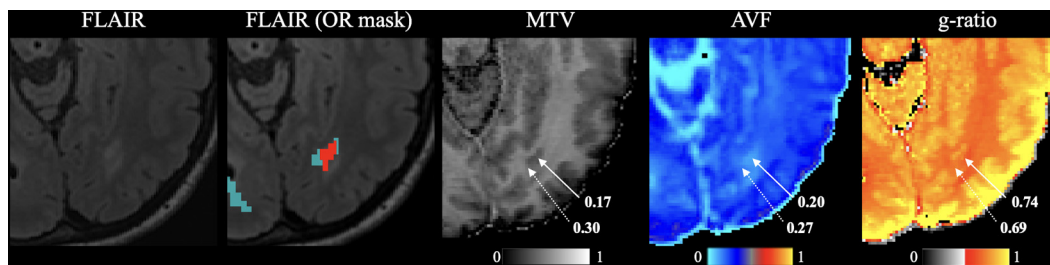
Representation of NAWM (light blue; second image) and lesional (red; second image) OR on axial FLAIR image and maps of corresponding MVF (third image), AVF (fourth image), and g-ratio (fifth image). Solid arrows indicate lesions. Dotted arrows indicate NAWM.
